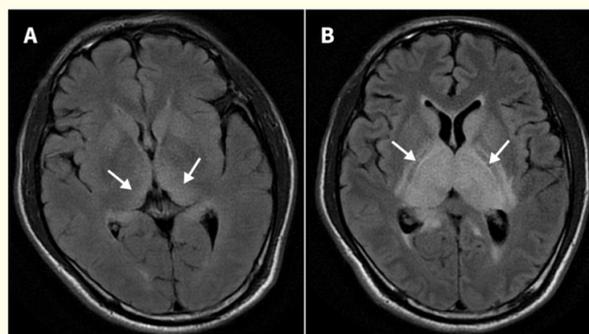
Courtesy ref no-19- (A) Brain magnetic resonance imaging (MRI) scan with fluid-attenuated inversion recovery (FLAIR) sequence on day 1 showing mildly high signal intensities in the bilateral thalami (arrows) in a 52-year-old man with Japanese encephalitis. (B) Brain MRI with FLAIR sequence on day 5 showing markedly high signal intensities in the bilateral thalami (arrows), caudate nuclei and internal capsules.
